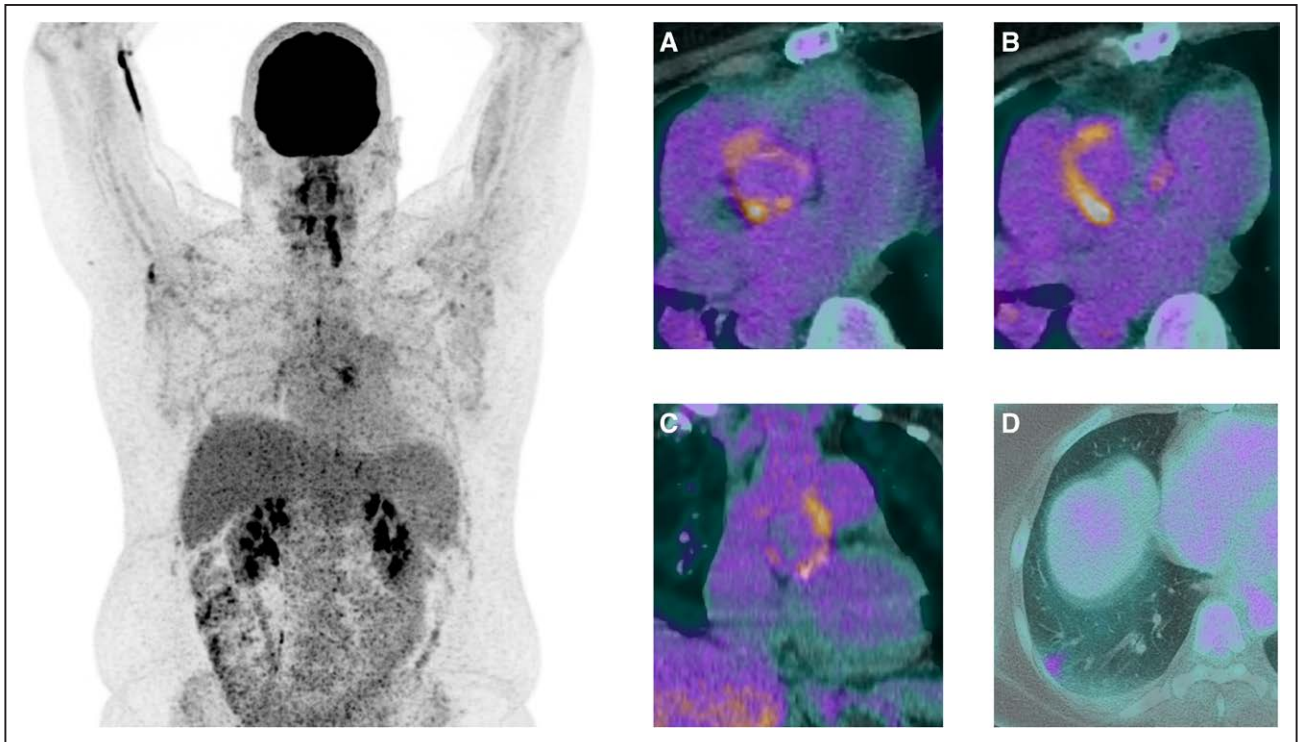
Positron emission tomography (PET)/computed tomography (CT) findings.
